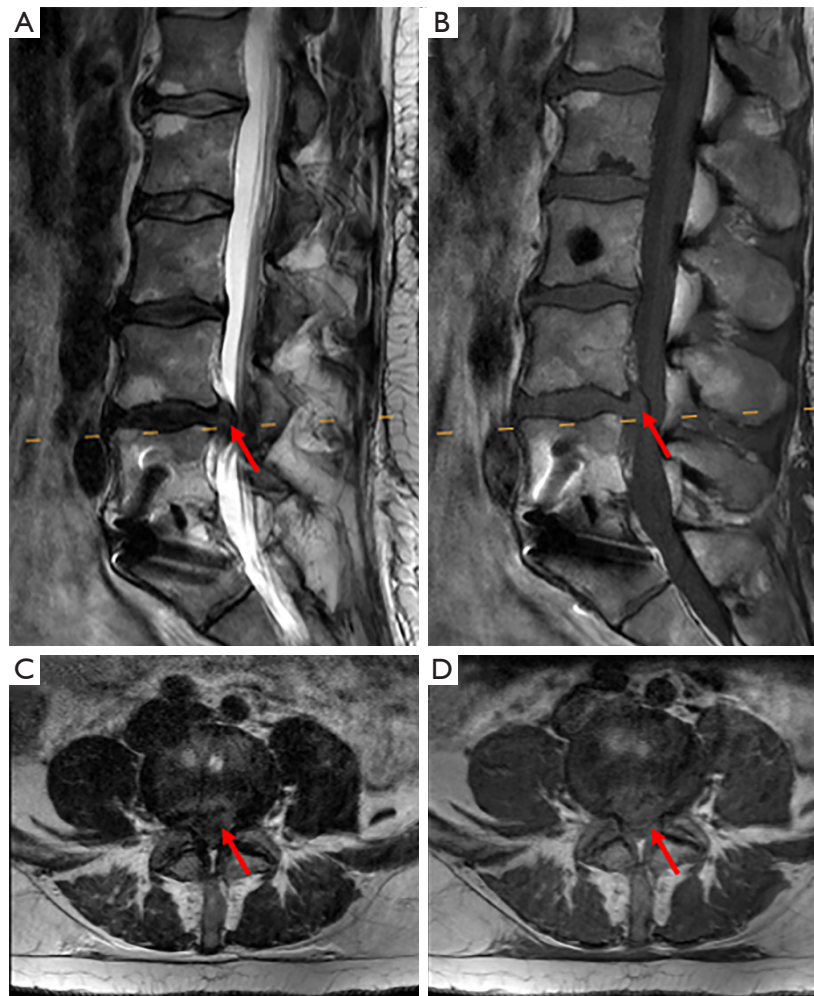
Our patient's lumbar disc herniation as visualized on magnetic resonance imaging. (A,B) T2-weighted image and (C,D) T1-weighted image. In each panel, the red arrow marks the disc herniation.
